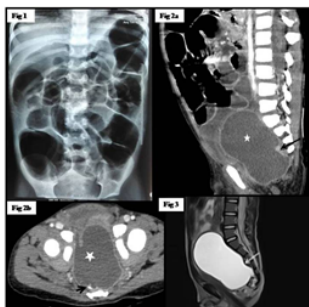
shows the x-ray abdomen image in supine position which reveals multiple dilated small and large bowel loops. The CECT sagittal (Fig 2a) and axial (fig 2b) sections which show the peripherally enhancing cystic mass(star) in the presacral space with eccentric enhancing soft tissue component (black arrow) and a small calcified spec (arrowhead) with mass effect. T2WI sagittal section (fig 3) is showing the cystic mass with eccentric soft tissue component (white arrow).
